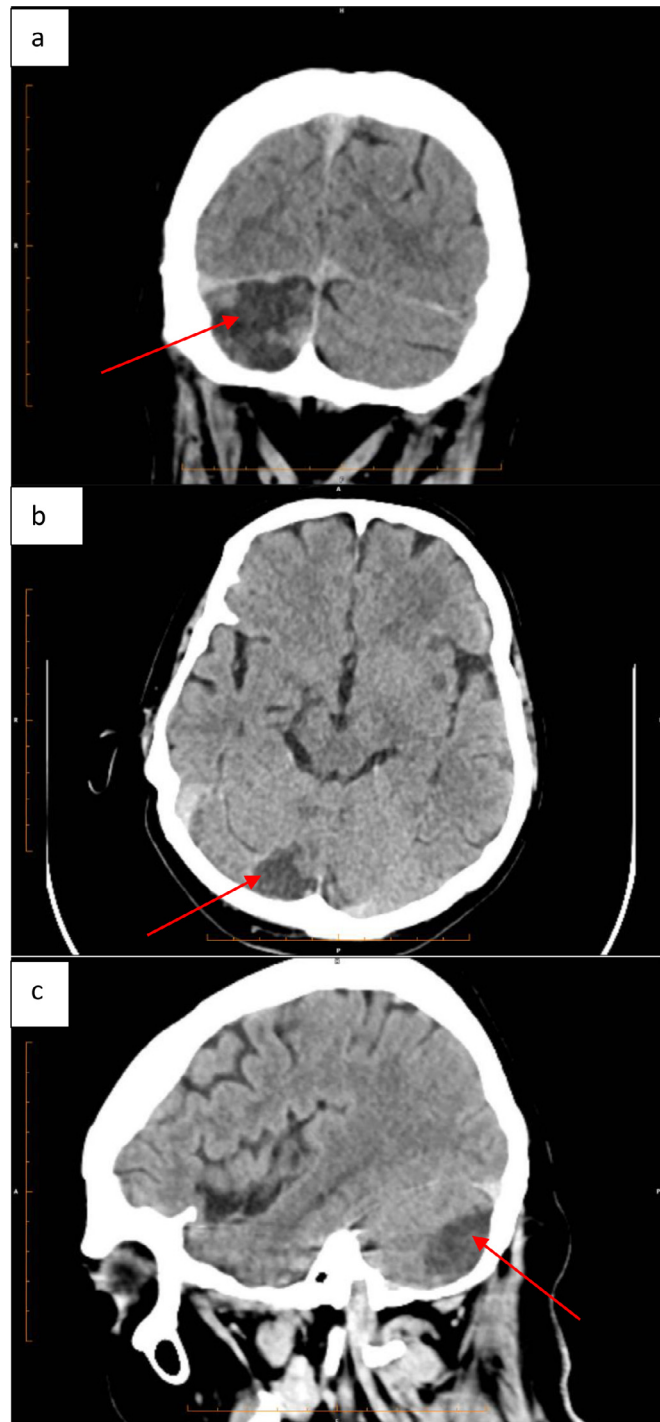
Head CT—Non-contrast right cerebellar hypodensity, suggesting an ischemic lesion, in transverse, sagittal and coronal view (A-C red arrows).
